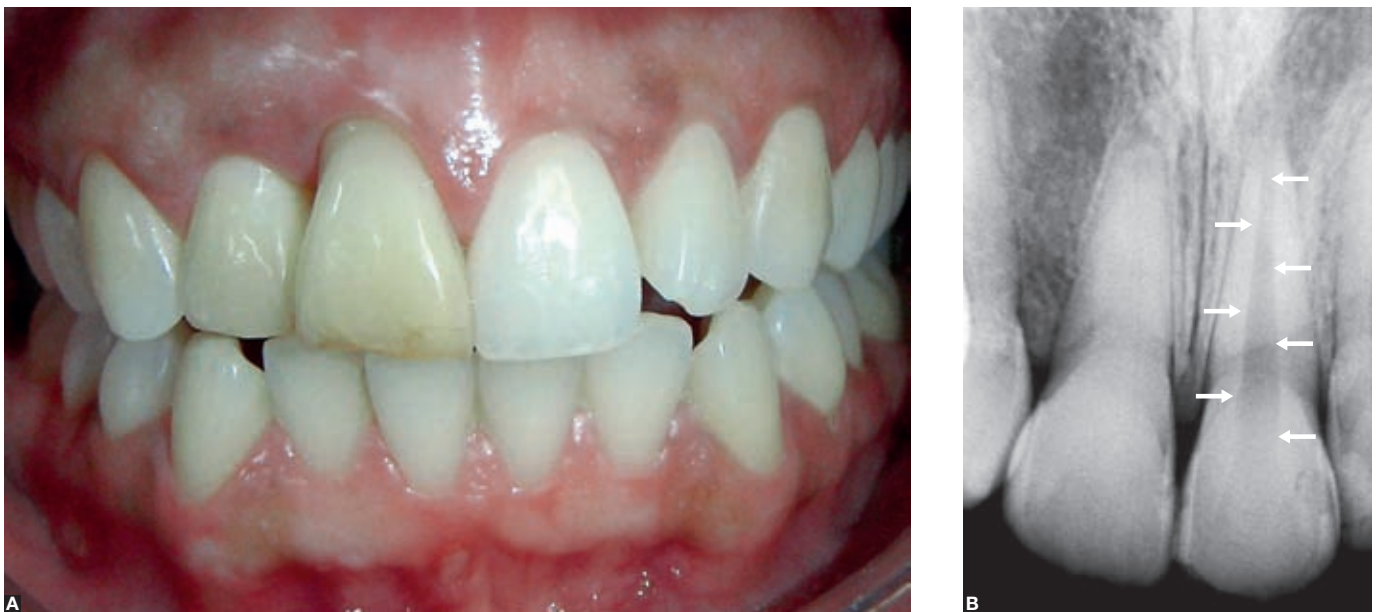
A) Discoloration of the left maxillary central incisor due to calcific metamorphosis in an intact tooth, associated with dental trauma, especially concussion. In this situation, the differential diagnosis with aseptic necrosis of the pulp was defined according to radiographs (B), which showed poorly defined pulp margins, typical of calcific metamorphosis of the pulp, when compared with the normal neighboring tooth (arrows).
